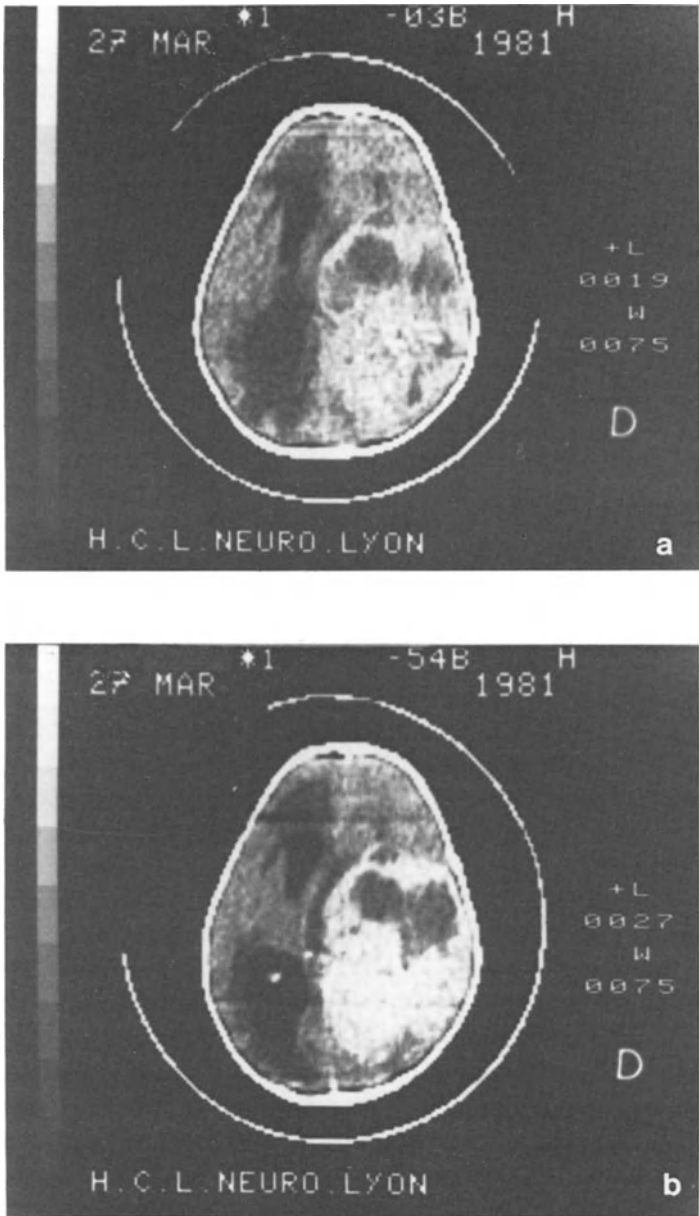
Infantile grade IV ependymoma: huge hemispheric tumor including solid and necrotic areas. a) Pre-contrast CT. b) Post-contrast CT
